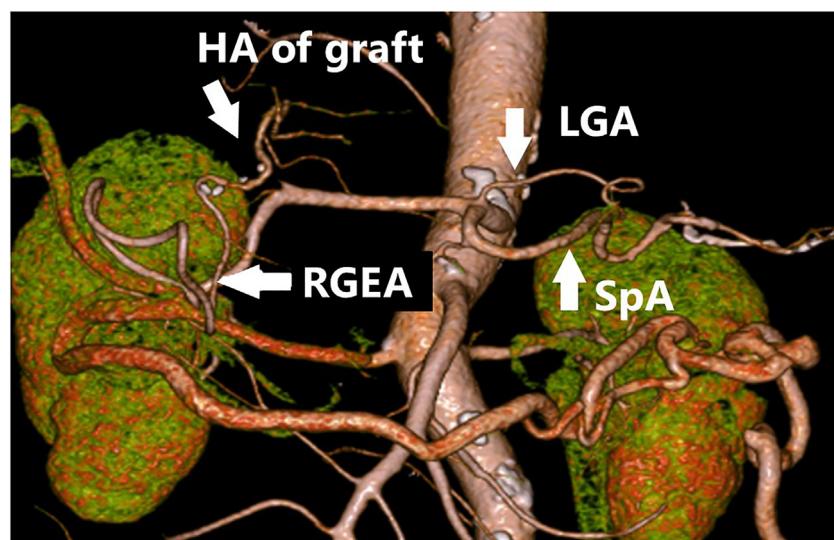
Three-dimensional computed tomography (CT) showing vessels around the stomach. The arrow indicates the left gastric artery (LGA), the right gastroepiploic artery (RGEA) anastomosed to the right hepatic artery in the right lobe of the liver graft (HA of graft). We only found small branches divided from the splenic artery (SpA) due to the history of splenectomy.
